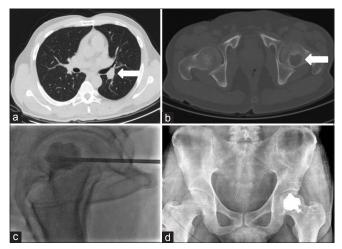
(a) Computed tomography image showing carcinoma of the lung. (b) Computed tomography image showing skeletal metastasis in the proximal femur with intact cortex all around. (c) Image showing percutaneous cement injection after radiofrequency ablation. (d) Radiograph showing cementoplasty of the proximal femur defect
